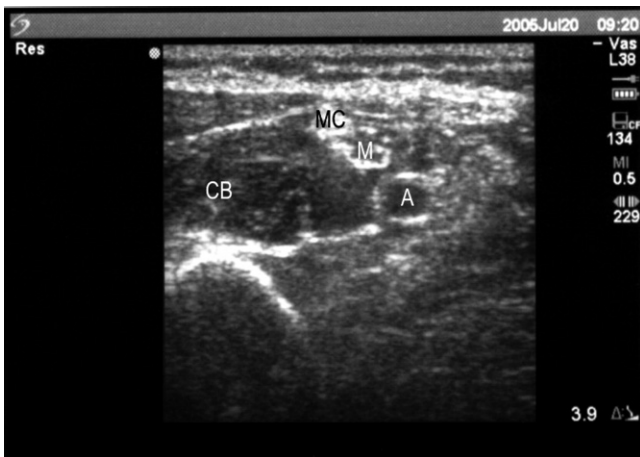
Transverse sonographic image of axillary region. After injection of local anesthetic solution, the large irregular structure thought to be the median nerve appears to consist of two separate structures, most likely the musculocutaneous nerve (MC) and median nerve (M) lying together, according to the nerve stimulation patterns. A = brachial artery; CB = coracobrachialis muscle.
